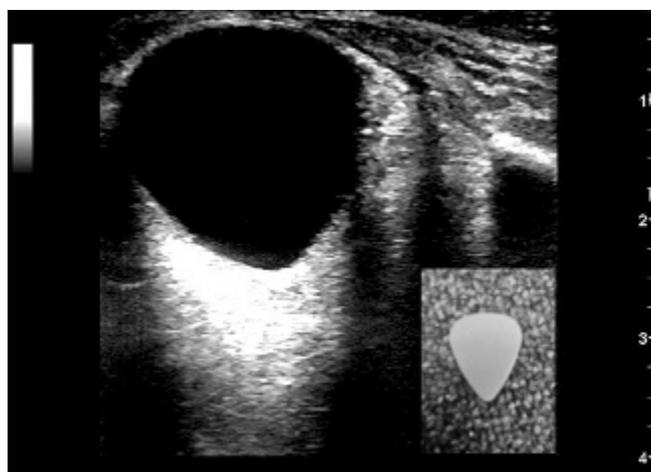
Ultrasound image demonstrating conical deformation of the left posterior ocular globe, mimicking the shape of a guitar pick (*insert*).
